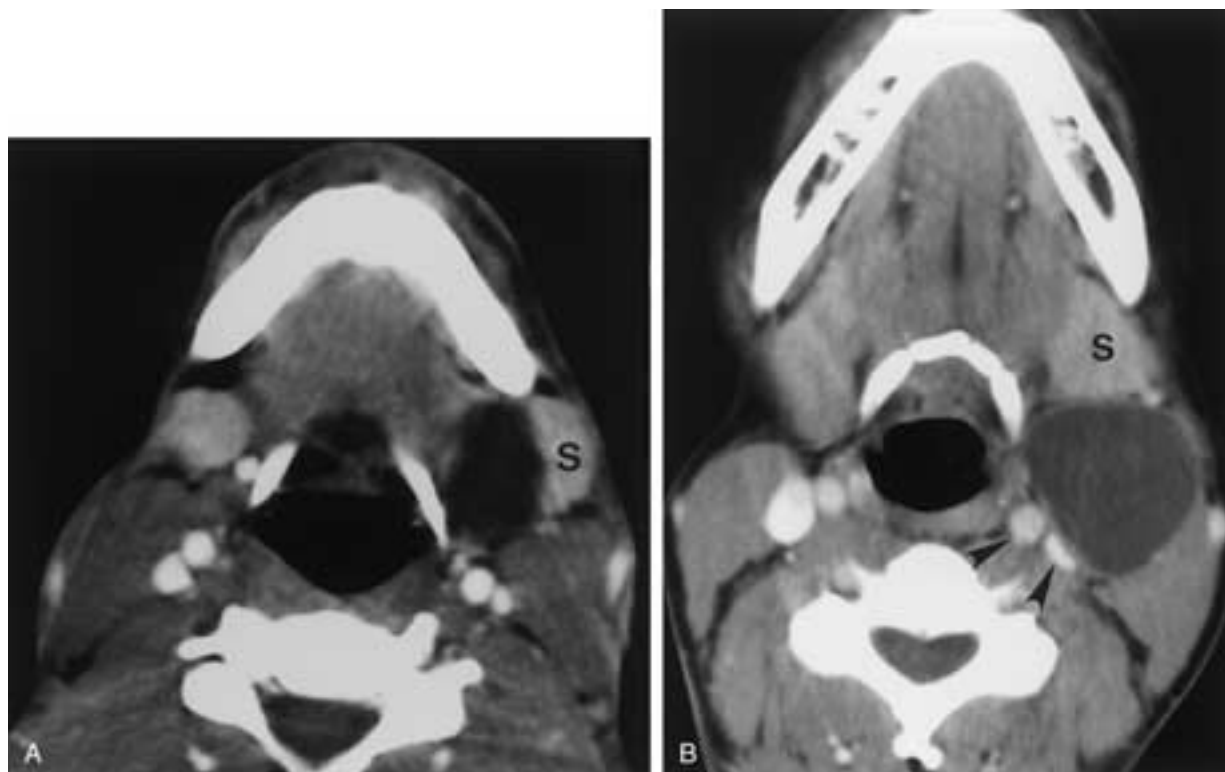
Ranula versus second branchial cleft cyst. Axial contrast-enhanced CT scans demonstrate characteristic displacements by a ranula (A) and a second branchial cleft cyst (B). The ranula displaces the submandibular gland (S) laterally, while the typical second branchial cleft cyst displaces it anteriorly. Both may produce a mass effect on the sternocleidomastoid muscle if large enough, but the second branchial cleft cyst will often displace the carotid space structures posteromedially (arrowheads in B).
